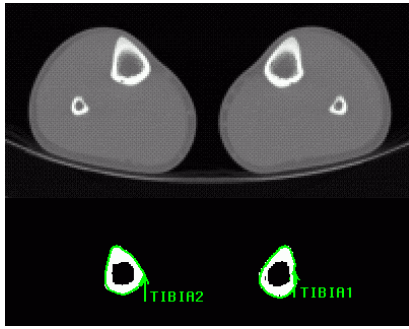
Edge detection of a transverse CT slice after the threshold process.
